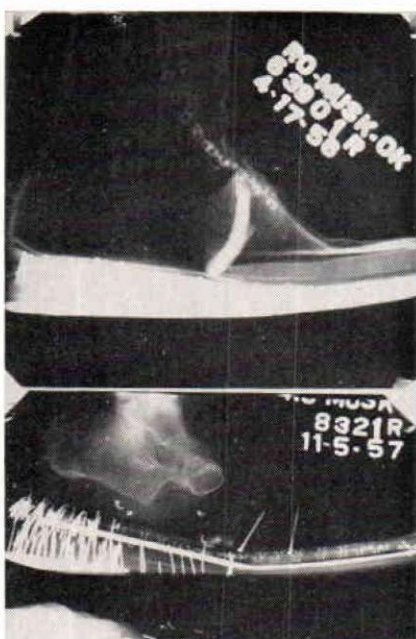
X-ray of Shoe and Chopart Amputation Stump in Shoe.
